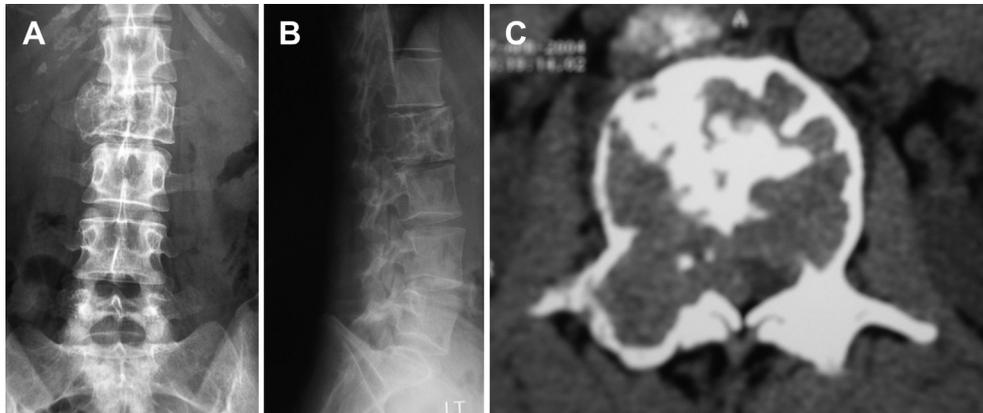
Radiographs of the lumbar spine shows the expansile lesion at L2: (A) anteroposterior and (B) lateral views; (C) computed tomography transverse section of L2.
